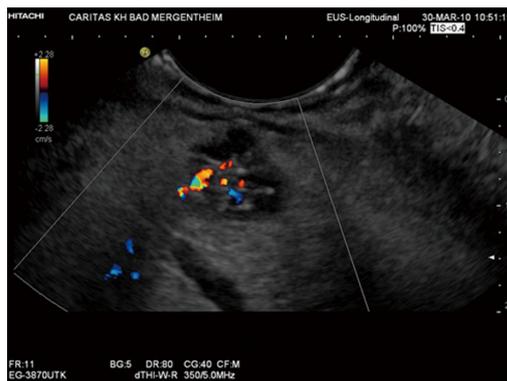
Typical oligocystic serous pancreatic neoplasia using endoscopic ultrasound.
